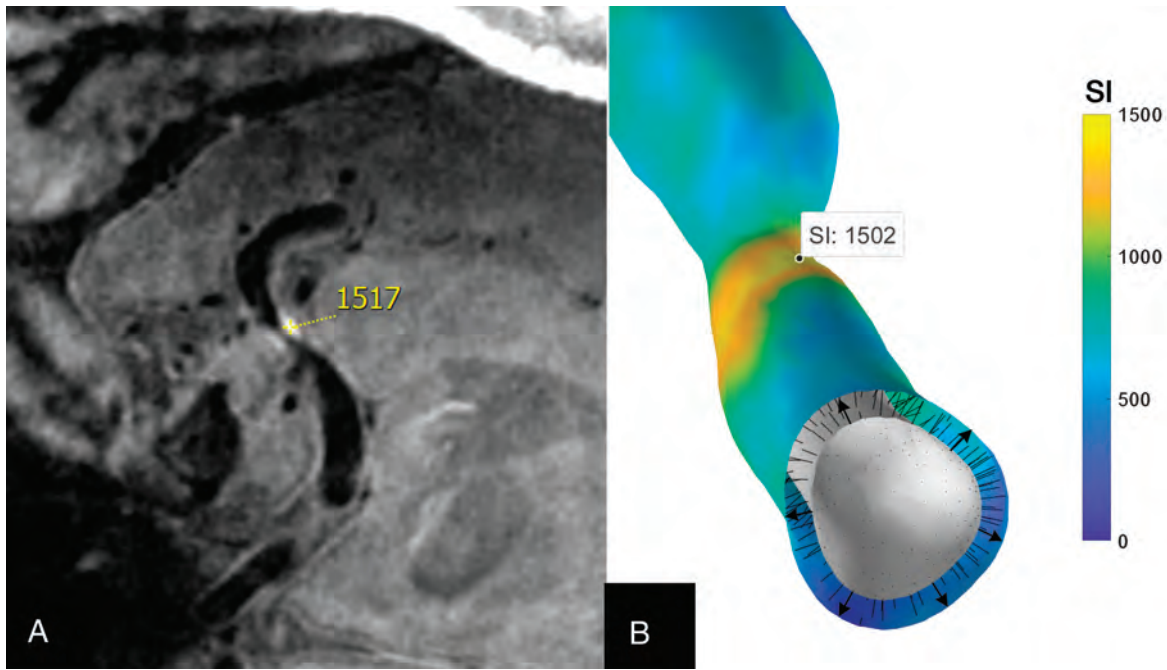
Generation of 3D enhancement maps. *A*, The SI sampled in high-resolution 7T MR imaging is almost the same as that generated with 3D mapping: 1517 and 1502, respectively. *B*, SI probes (arrows) extend from the arterial lumen to the plaque and contiguous vessel wall. An average of 125 probes or data points were generated per plaque, and 858, per arterial segment. This technique makes it possible to generate a detailed color map of Gd enhancement.
